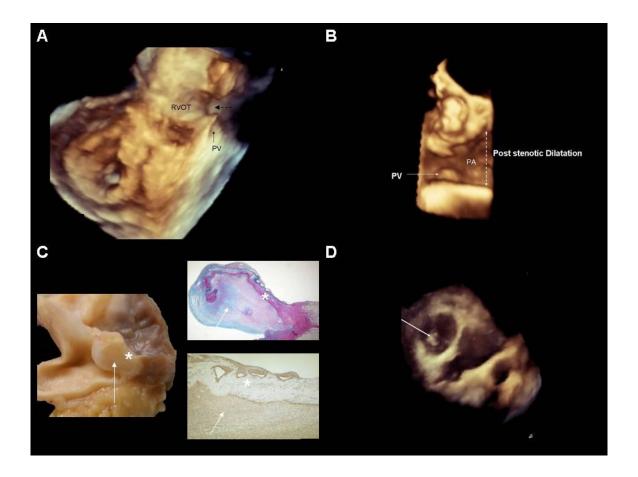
Three dimensional echocardiography of pulmonary valve. Right ventricular outflow tract (RVOT), pulmonary artery (PA).
